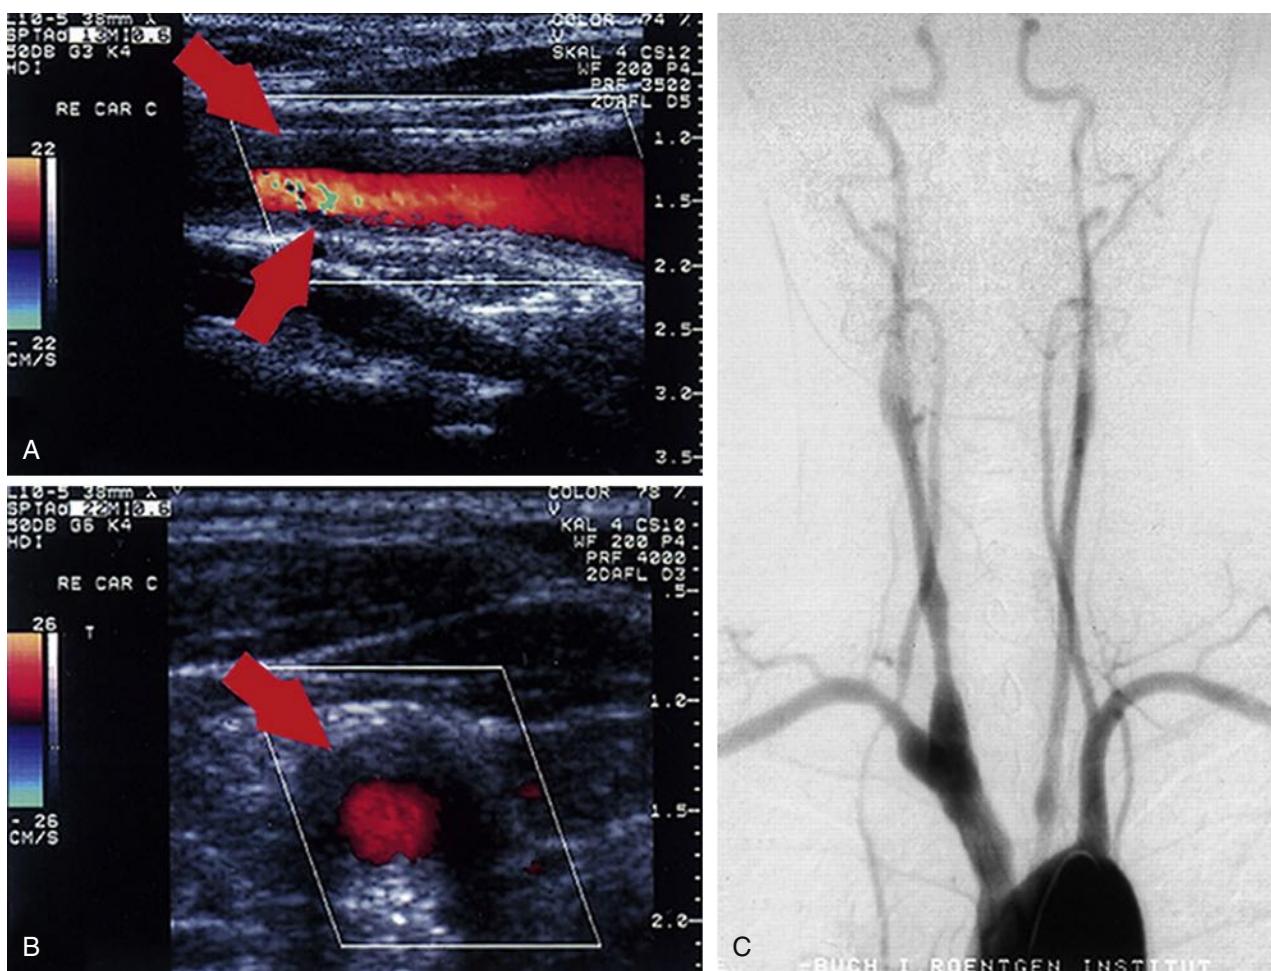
Patient with Early Takayasu Arteritis. (A and B) Ultrasound images: longitudinal plane (A) and transverse plane (B) of the right common carotid artery with the typical morphologic appearance of Takayasu arteritis indicated by arrows. (C) Angiography of the branches of the aortic arch, confirming the ultrasound diagnosis and revealing narrowing of up to 40% as well as post-stenotic dilations at the right common carotid artery, the left proximal common carotid artery, the proximal right subclavian artery, and the proximal right vertebral artery. (From Schmidt WA, et al. Diagnosis of early Takayasu arteritis with sonography. *Rheumatology (Oxford)*. 2002;41:496–502.)
